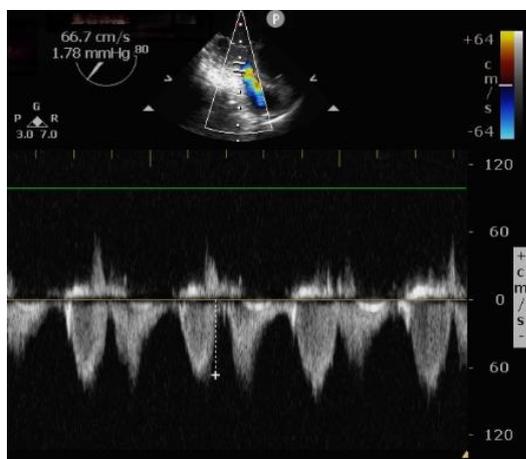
Transesophageal echocardiography examination before operation showed a bimodal flow velocity of 66.7cm/s across the tricuspid valve.
